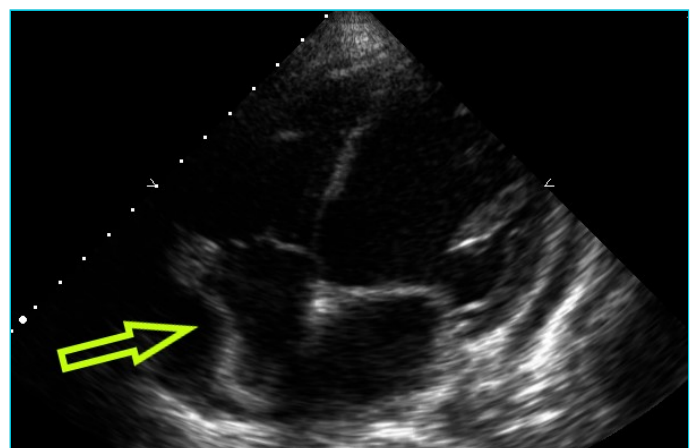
Cardiac tamponade in echocardiography
